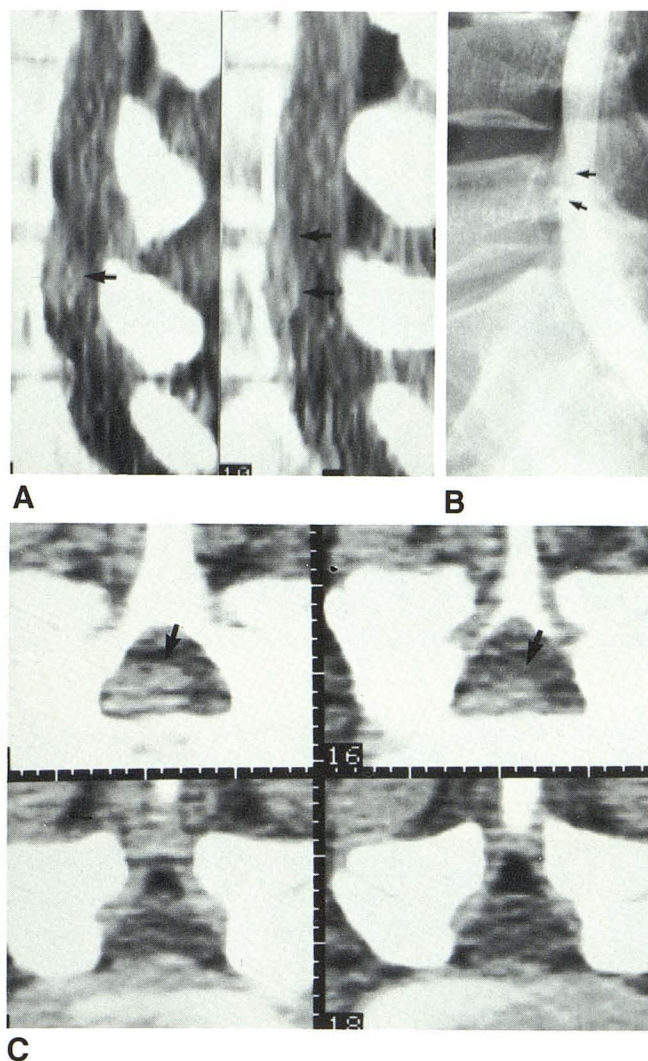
Herniated disk, caudad displacement. A, Sagittal reformation demonstrates caudad displacement of large herniated disk fragment (surgically proven) (arrows). B, Lateral myelogram confirms this finding. C, Axial CT images also reveal disk fragment inferior to interspace, but relation is less obvious (arrows).
